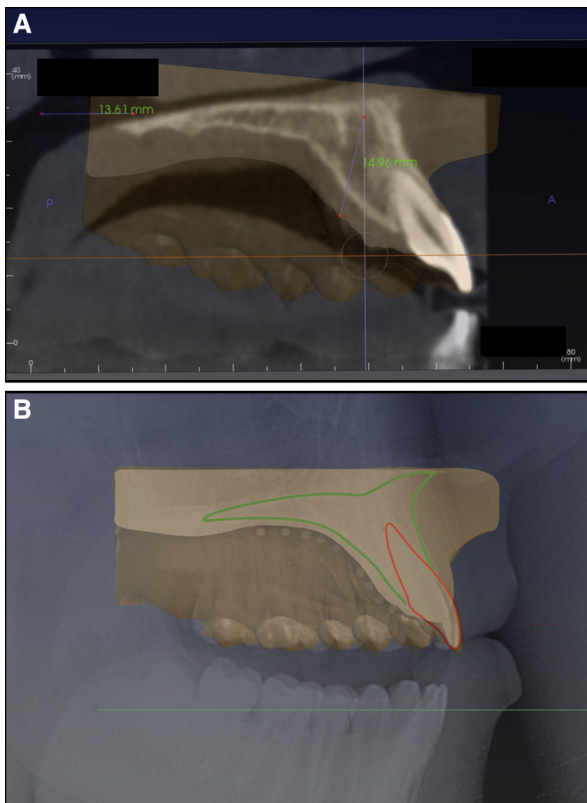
Superimposition of digital model on CBCT and lateral cephalogram.
